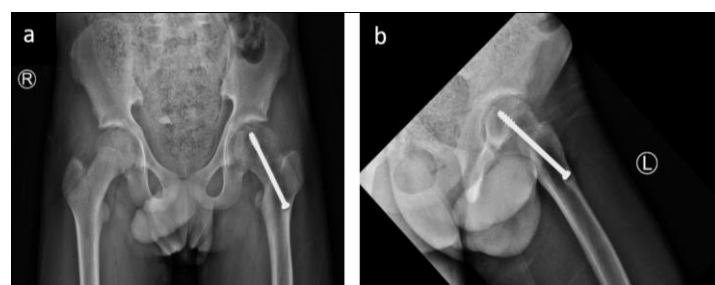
Radiographs of left hip anteroposterior (a) and lateral (b) views after 36 weeks follow-up post-surgery.
